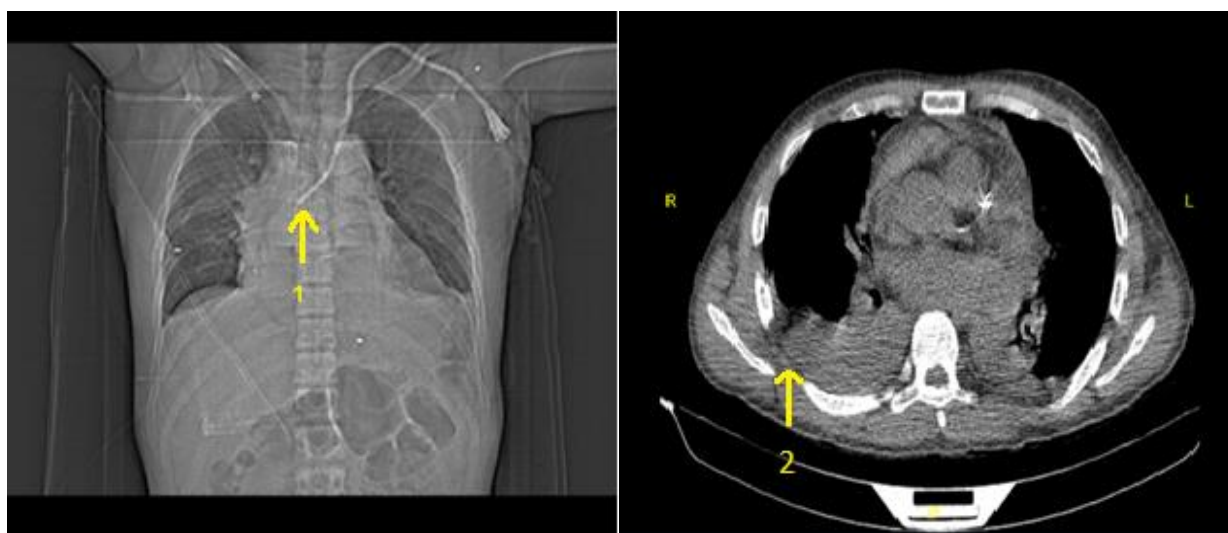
Spiral CT scan of the lungs without contrast shows moderate right (2) and mild left pleural effusion with passive collapse of adjacent segments. Marker 1 shows the catheter tip.
